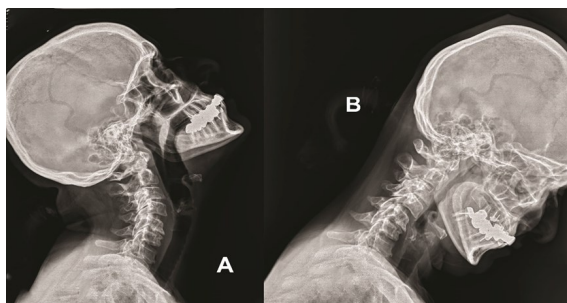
Lateral Dynamic X-ray in extension A and flexion B flexion showing no anterior/posterior subluxation of the C1.
